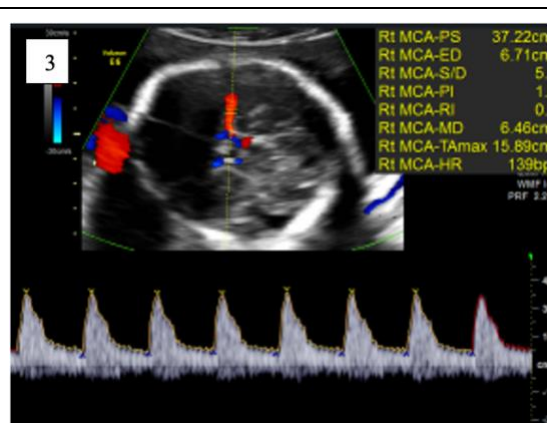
Ultrasound at 31 weeks' gestation with normal peak systolic velocity on middle cerebral artery dopplers.
